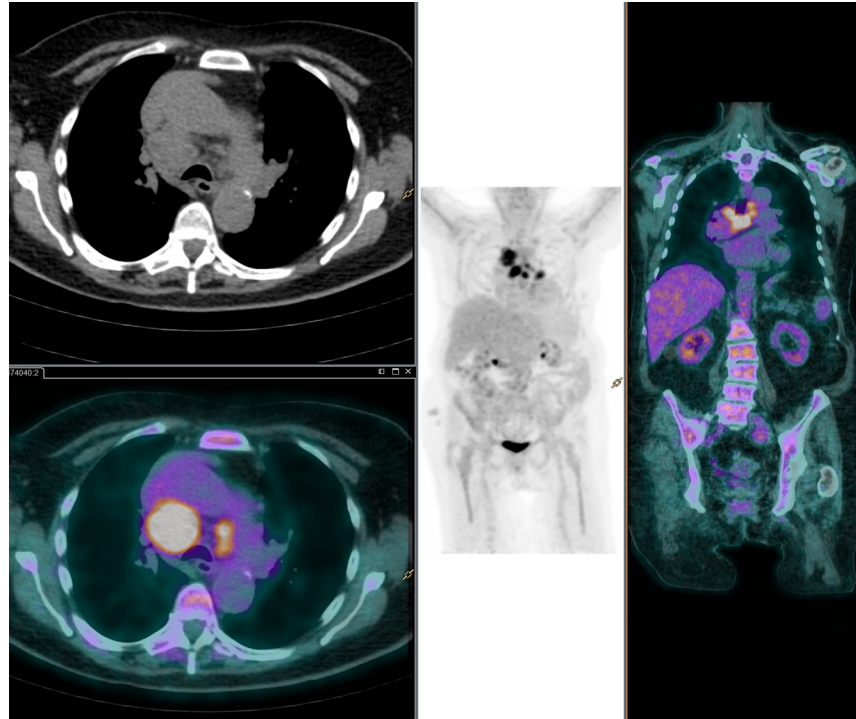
^{18}F -FDG-PET/CT images. A 89-year-old woman ^{18}F -FDG PET/CT with diagnostic of polymyalgia rheumatica. PET/CT images showed multiple mediastinal nodules with increase ^{18}F -FDG uptake and bone marrow glucose hypermetabolism. The patient was finally diagnosed of in a lymphoproliferative process. No treatment was administered due to age and other concomitant pathologies.
